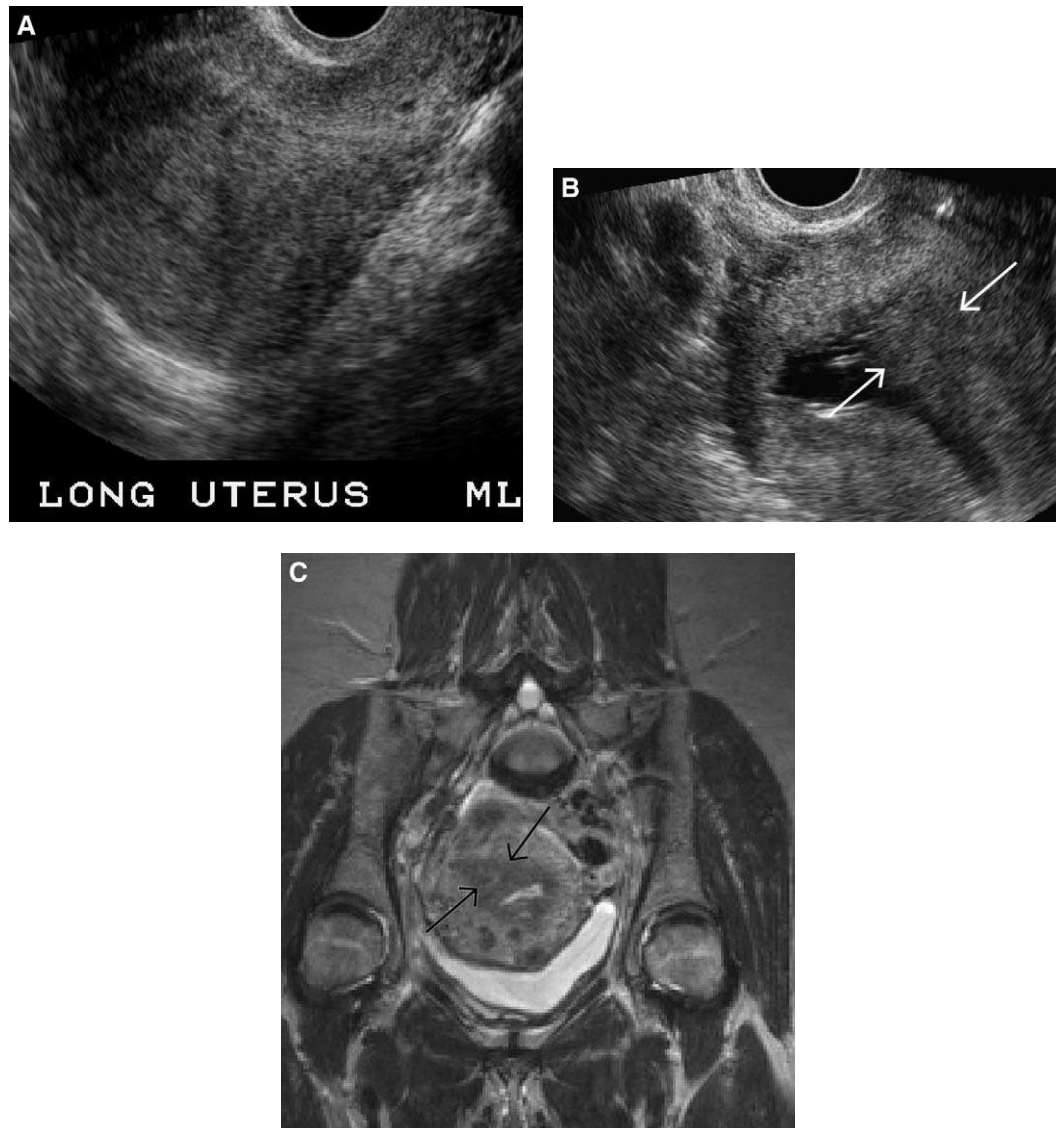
Uterine myoma suspected by clinical findings. (A) Transvaginal sonography demonstrates enlarged uterus with possible mass. (B) Sonohysterography outlines ill-defined mass projecting into the cavity (*arrows*). (C) MR imaging demonstrates that the mass is adenomyosis and not a myoma (*arrows*).
